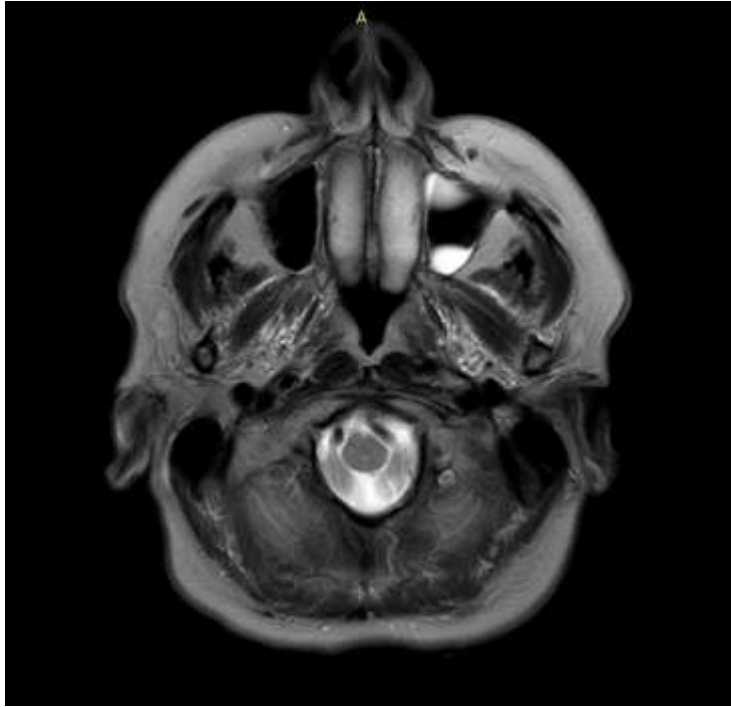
Axial MRI brain T2W-MV image for patient number 16 shows mild mucosal thickening of the antrum.
